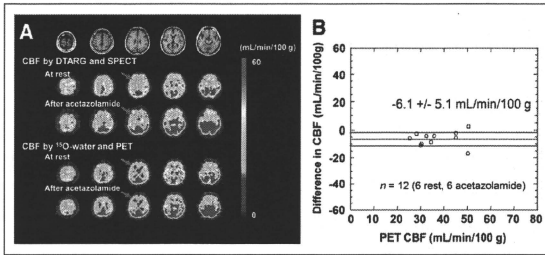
shows MR and CBF images at rest and after acetazolamide obtained with DTARG SPECT and  $^{15}\text{O}$ -water PET in a 73-y-old male patient (63 kg) with right internal carotid artery occlusion and left internal carotid stenosis. The MR images do not show any evidence of cerebral infarction in either hemisphere. Rest CBF was reduced bilaterally in the frontal-to-parietal regions, and acetazolamide increased CBF in left parietal regions but not in the right parietal area. DTARG CBF indicated the loss of vasoreactivity in the right internal carotid artery stenotic area. These findings were consistent with those from the PET evaluation. An additional example is shown in Supplemental Figure 4 for a 74-y-old female patient (48 kg) with left internal carotid artery stenosis, for whom MR images did not show cerebral infarction. DTARG CBF demonstrated preserved CBF in both hemispheres but reduced CBF reactivity in the left middle cerebral artery territory. The findings were again consistent with those
